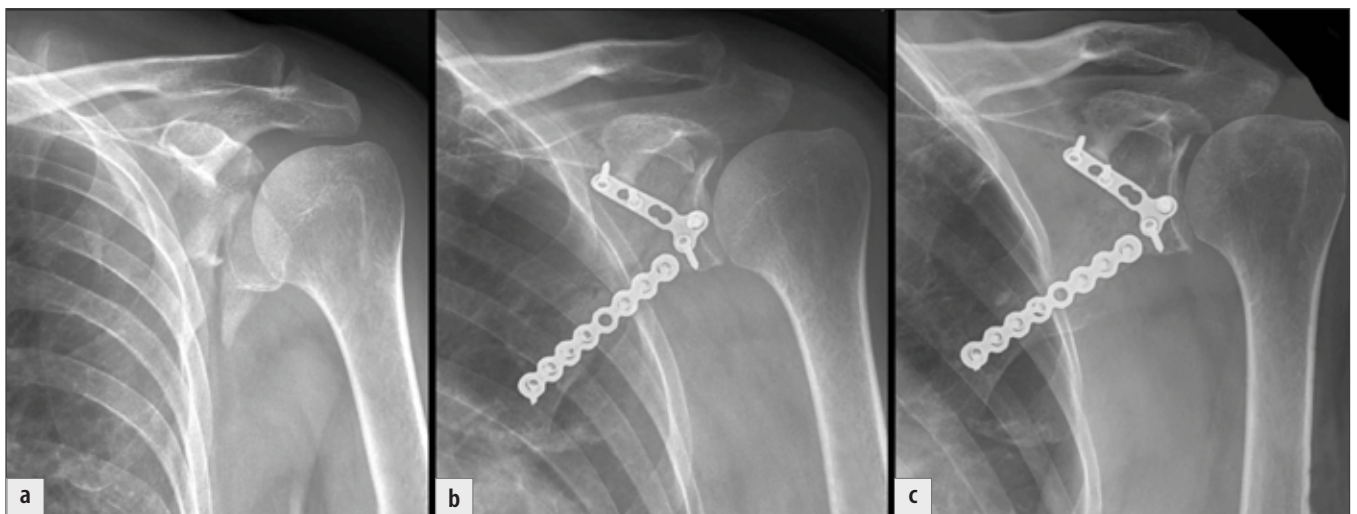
Radiological outcome of the operation: a) post-injury radiograph; b) postoperative radiograph; c) 1 year postoperatively.
